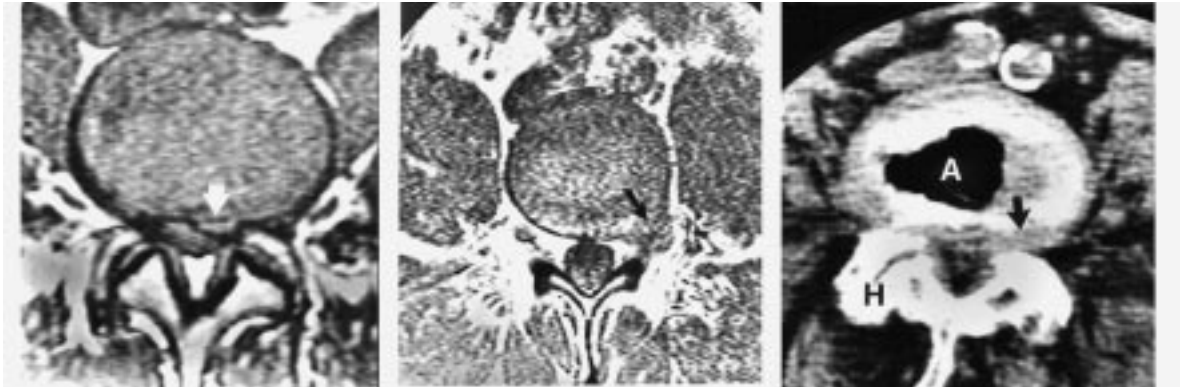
Preoperative neuroradiologic studies: Left: MRI demonstrating disc herniation (arrow) into left lateral recess. Middle: MRI showing left foraminal herniated disc (arrow) compressing the exiting nerve root. Right: CT showing air (A) consistent with degenerative disc disease, superimposed facet hypertrophy (H) causing stenosis and asymmetrical disc protrusion (arrow) extending to the left lateral recess.
